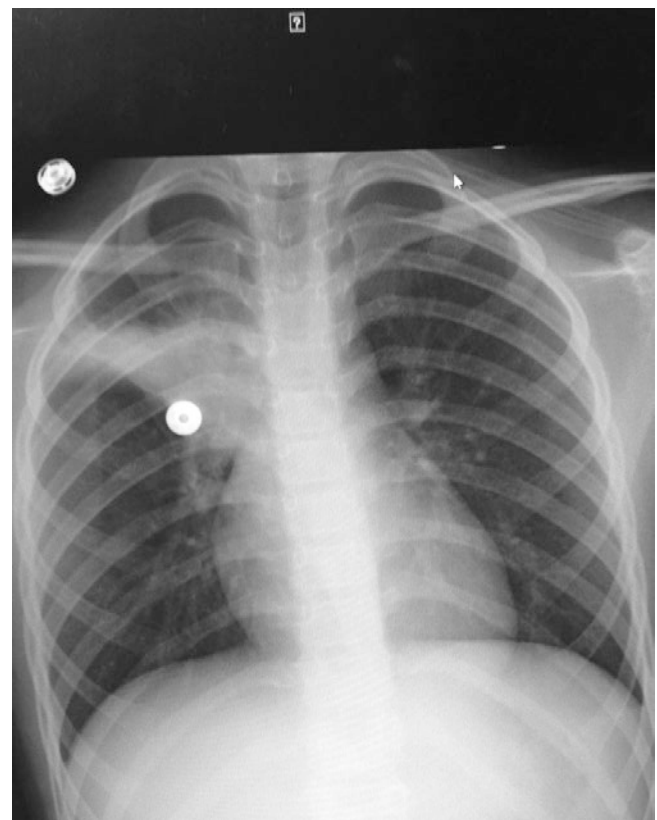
A 9-year-old female presents with cough and fever. Chest radiograph shows right upper lobe infiltrate.
